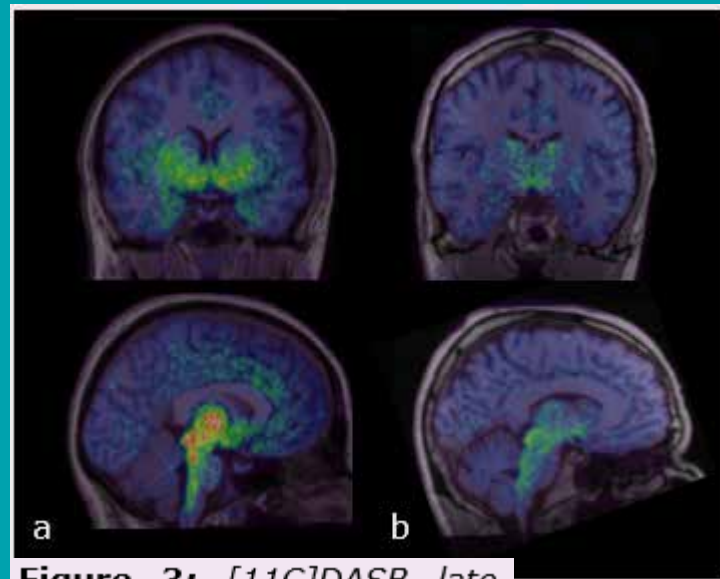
$[^{11}\text{C}]\text{DASB}$ late add images (40-90 minutes), co-registered with the individual MRI of a) a presymptomatic HD gene carrier, b) a healthy control. Coronal and sagittal sections. DASB binding is increased in brainstem and basal ganglia regions indicating increased serotonin transporter availability.
